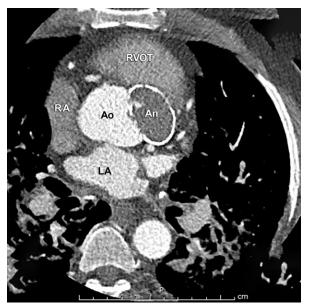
Computed tomogram of the heart with contrast medium shows that the $4.5 \times 3 \times 4.7$ -cm mass arises from the right coronary cusp, is partially thrombosed and calcified, and is probably a thrombosed pseudoaneurysm of the right coronary cusp.
